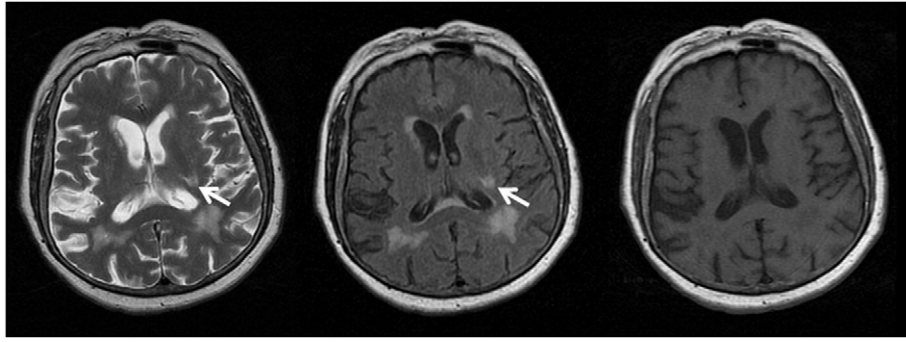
Cranial MRI showing chronic lacunar lesion in the posterior putaminal region.
